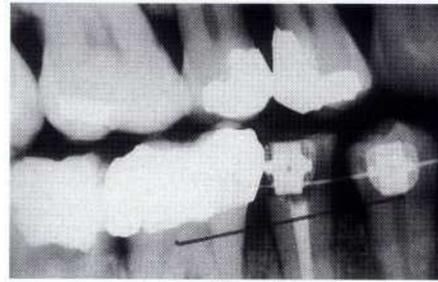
Radiograph of the patient shown in Figure 19-41 showing elevation of the mandibular second premolar.
